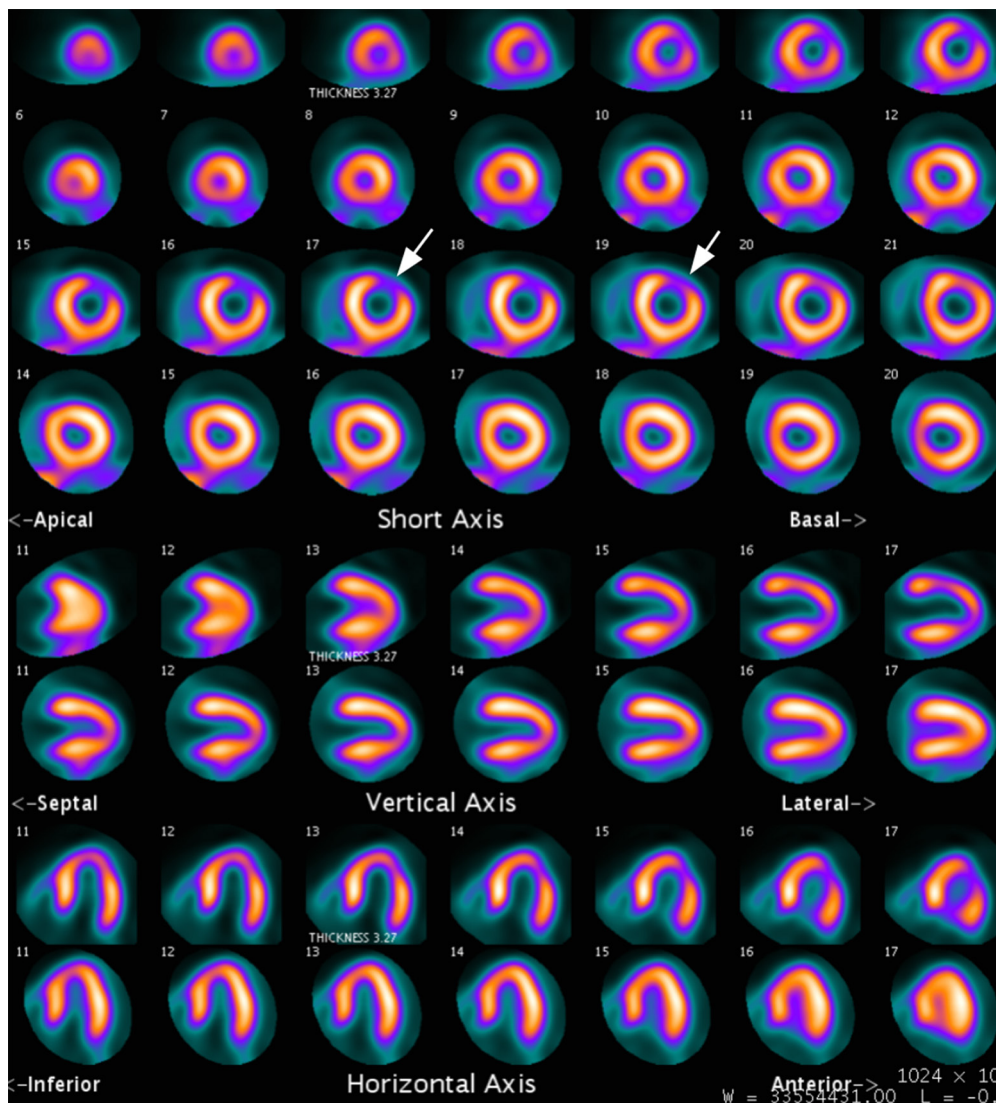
Abnormal ¹³N-ammonia PET CT MPI images. The images show small moderately severe anterolateral wall ischemia (arrows).
